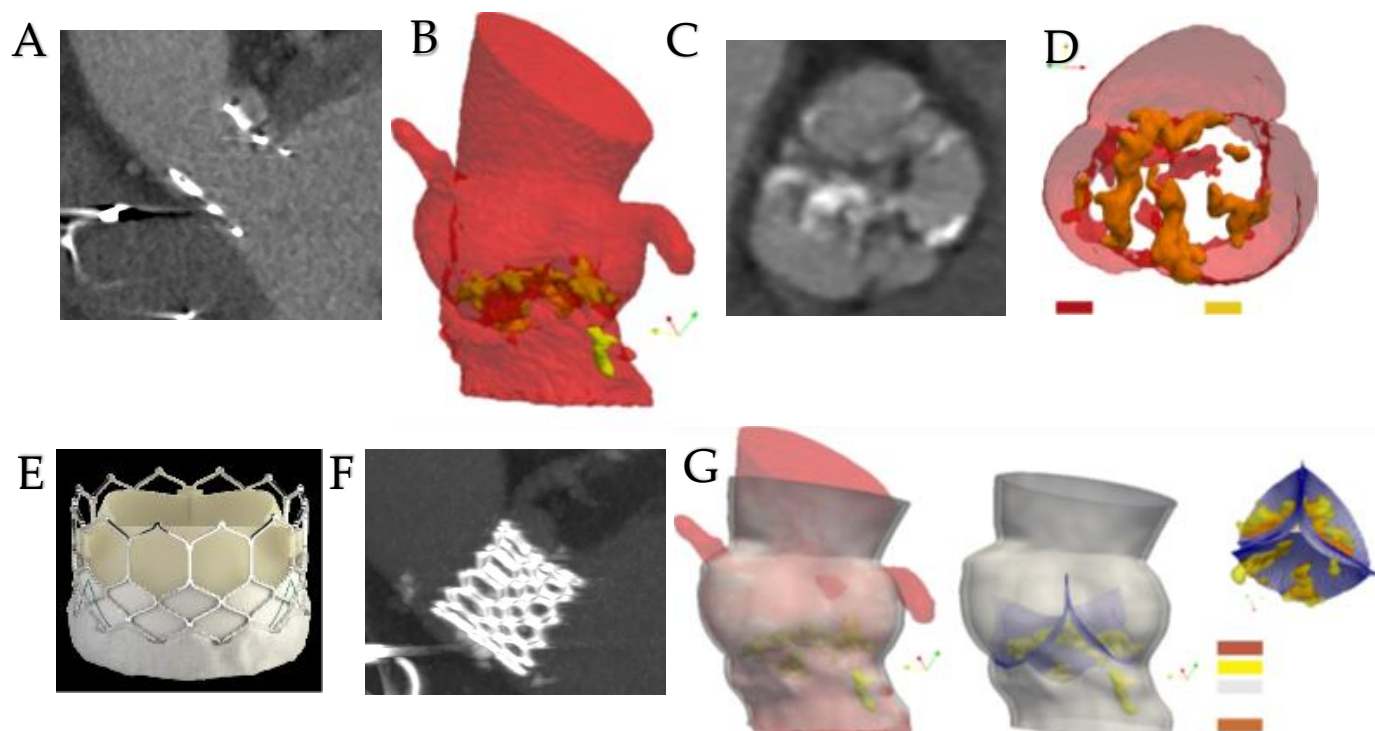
Up : with the use of ITK-Snapv 2.4 the data extracted from the CT images (A, C) are processed to highlight the images of the aortic lumen (B, red) and calcium deposits (D, yellow/orange). Down : a first generation of balloon-expandable TAVI Sapien (E ; Edwards Lifesciences, Irvine, Calif) is used to treat severe AVS (F). G : aortic lumen morphology as well as the calcium conglomerates are extracted with the use of STL files. Left : the lumen of the aortic root (red) and the calcifications (yellow) are superimposed to the aortic wall model (gray). Center : the enclosed native leaflets (blue mesh) correspond perfectly to the real leaflets with calcifications obtained by processing CT images (A, C). Right : The top view is shown. Abbreviations : AVS, aortic valve stenosis ; CT, computed tomography ; STL, stereolithographic ; TAVI, transcatheter aortic valve implantation
